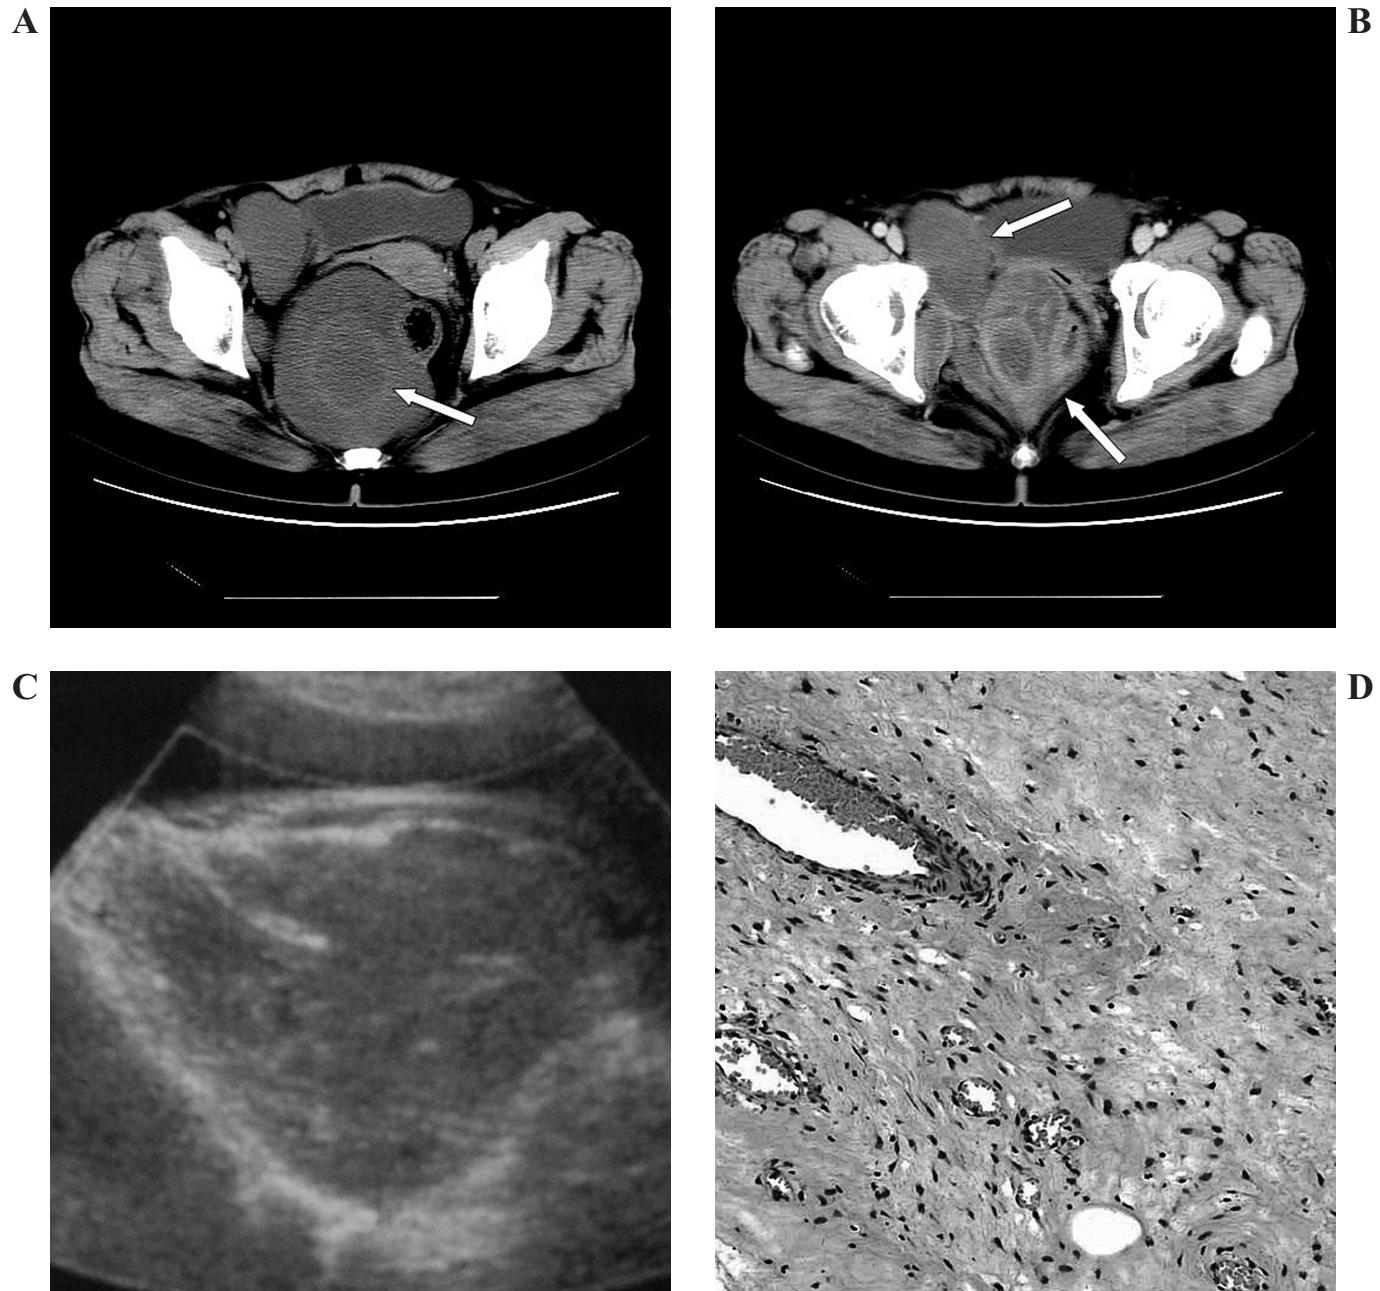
A) Unenhanced CT shows layering internal pattern (arrow). B) Enhanced CT at a more caudal level shows that the tumor is polypoid and has an appearance of swirling strands, displacing the rectum, vagina, bladder, and levator ani muscle (arrow). C) Sonography reveals a hypoechoic soft tissue mass that appears cystic. D) The tumor is characterized by hypocellular myxoid stroma with numerous variably sized blood vessels.
